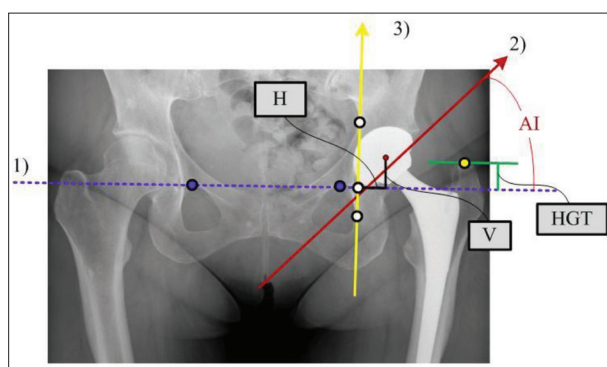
Representation of radiographic measurement parameters; Line 1 – horizontal; Line 2 – for AI determination; Line 3 – Köhler line; AI – acetabular inclination; HGT – height of greater trochanter; V – vertical offset; H – horizontal offset
